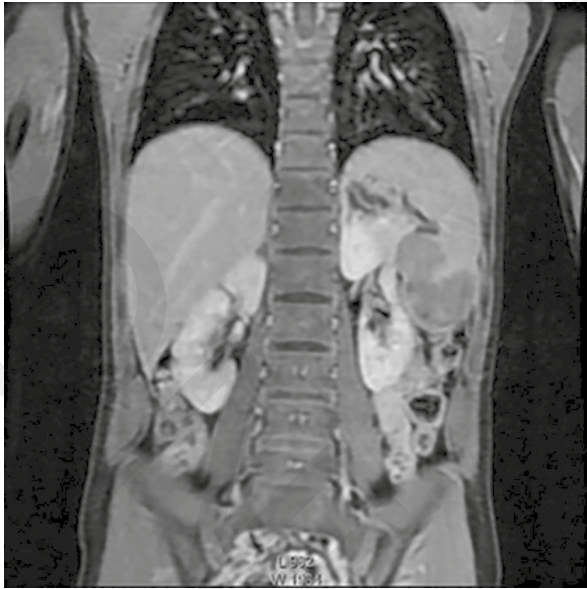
Magnetic resonance imaging of the spleen in the coronal plane (April 2024), showing the splenic lesion
